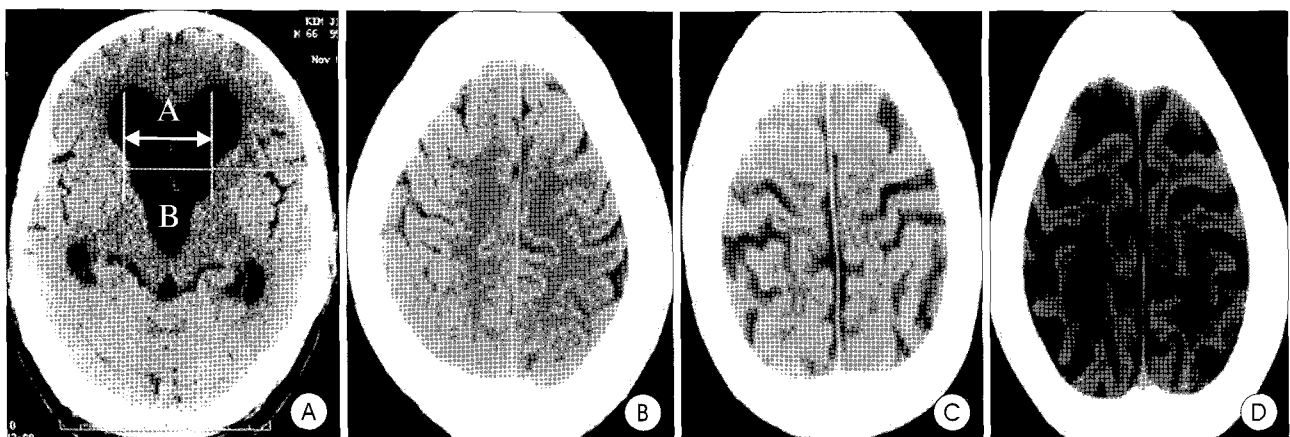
Brain computed tomography finding in hydrocephalus (A : ventricular size. B,C,D : cortical gyral atrophy). Ventriculocranial ratio=A/B,C,D. Convexity gyral atrophy. B : non, C : moderate, D : severe.
